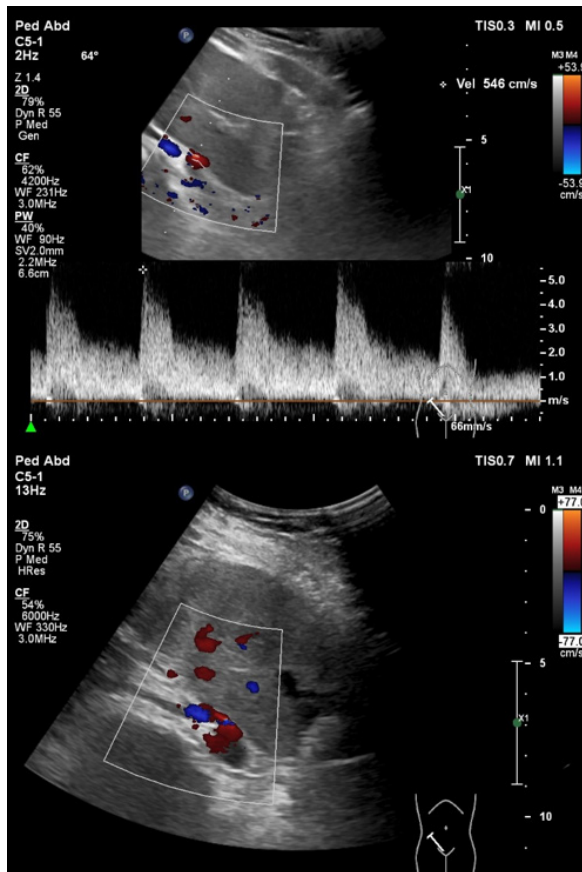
Doppler ultrasonography of renal artery with a filled bladder: right renal artery arising from the right common iliac artery with the bending and peak systolic velocity (PSV) 5.5 m/s.
